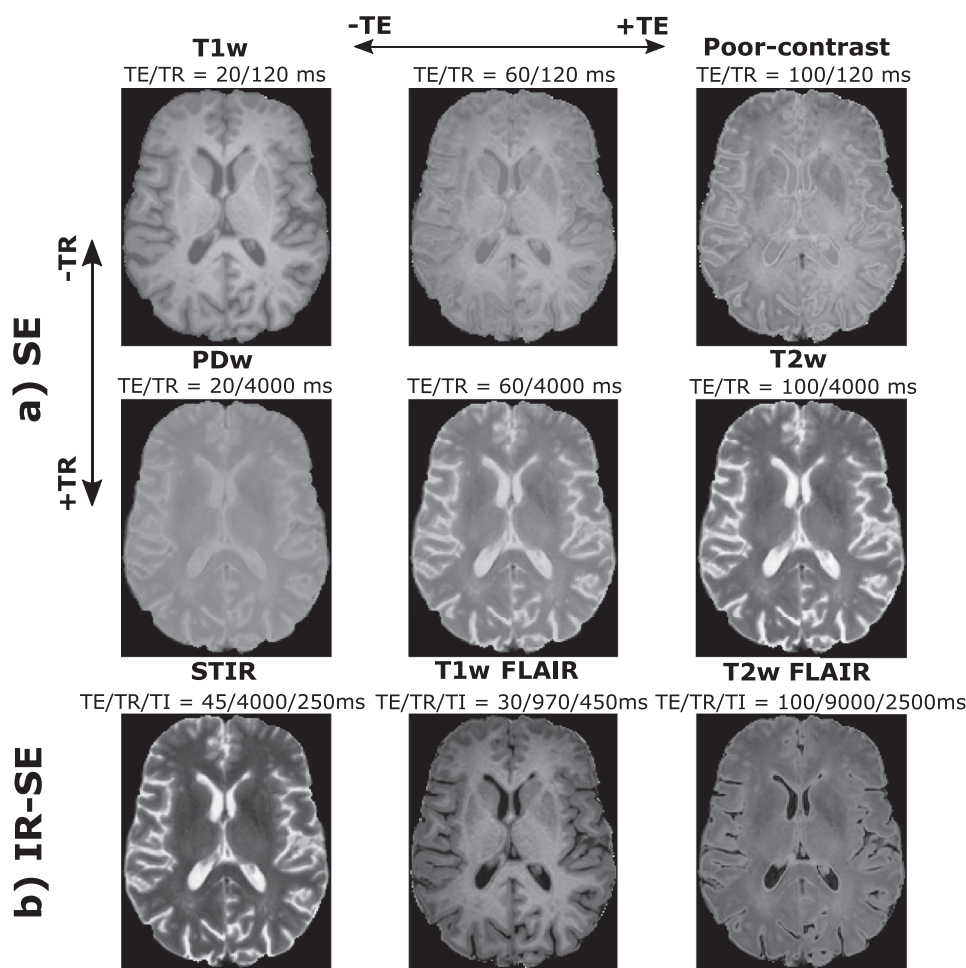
A representative axial slice of other weighted images synthesized varying the sequence parameters from a set of the T1, T2, and PD maps computed by the CNN. a) Weighted images synthesized for a spin echo (SE) sequence with different TE and TR corresponding to T1w, T2w and PDw image modalities. b) Weighted images synthesized for an inversion recovery spin echo (IR-SE) sequence with different TE, TR, and TI corresponding to short-TI inversion recovery (STIR), T1w FLAIR, and T2w FLAIR image modalities. Note that the unlabeled images correspond to sequence parameter combinations which lead to weighted images with undefined contrast.
